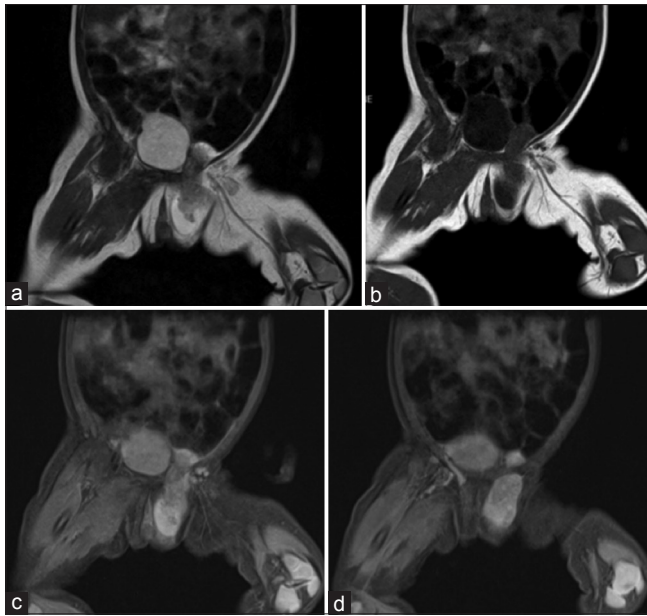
Coronal T2-weighted imaging, T1-weighted imaging (T1-WI) and short tau inversion recovery magnetic resonance images shows a hyperintense tubular structure in the left inguinal canal extending to left labia majora (a, c and d) with hypointense heterogeneous structure inside (a and c). This lesion is hypointense on T1-WI (b)
